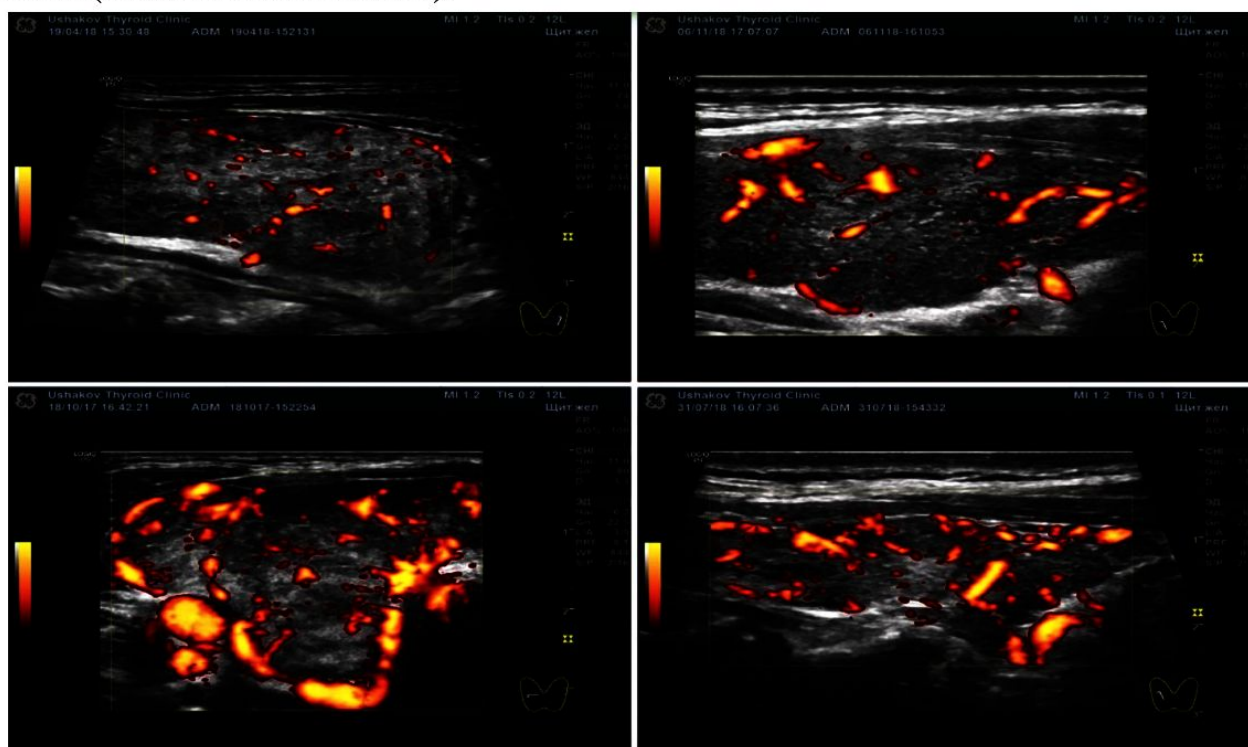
EDC mode: Strong Doppler ultrasound. Various options for enhancing blood flow in the thyroid gland lobes [9].
